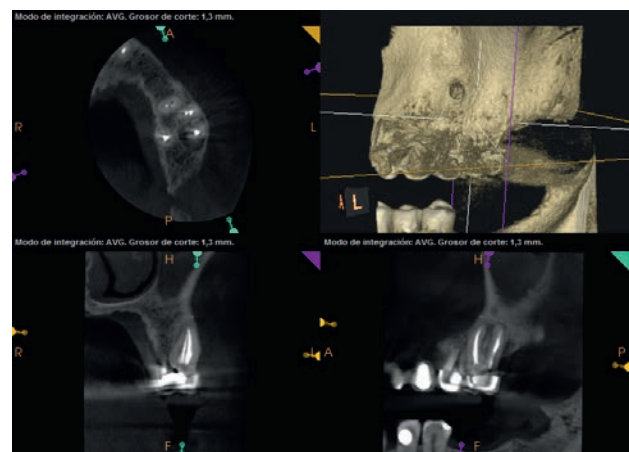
6 months control CBCT image after upper left first molar retreatment, which shows a clear reduction in the size of the previous periapical radiolucent lesion.
